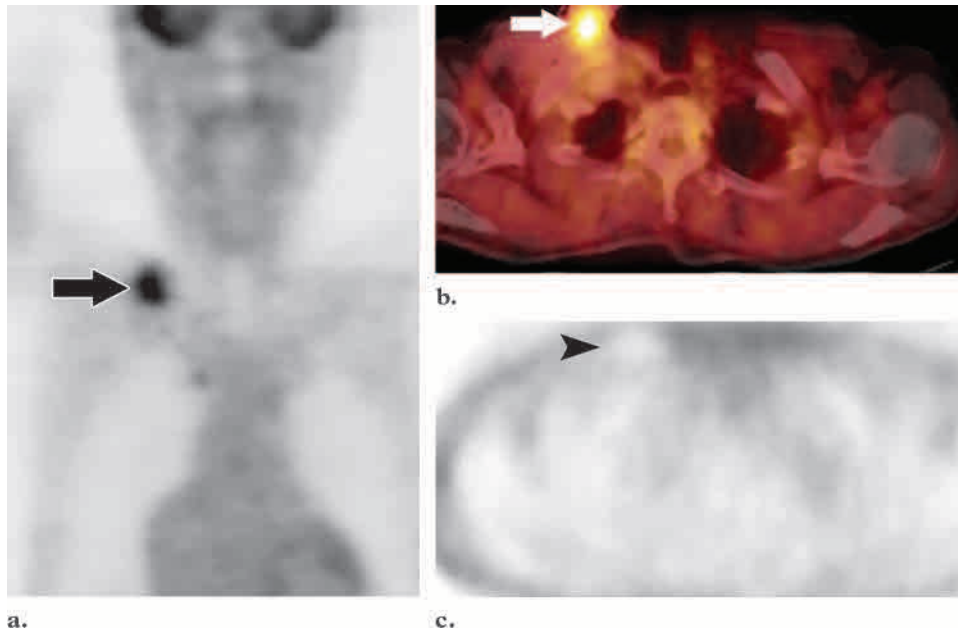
CT attenuation artifact from an implantable catheter port. (a) Coronal PET scan demonstrates focal intense FDG accumulation in the right supraclavicular area (arrow). (b) Axial fused PET-CT scan helps localize the FDG activity to an implanted catheter port (arrow). (c) Axial uncorrected emission image helps confirm that the abnormality (arrow-head) is an attenuation correction artifact caused by the extremely high attenuation of the port.
